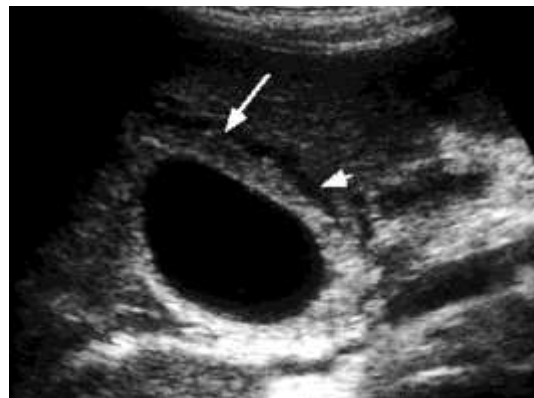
Ultrasound of the right upper quadrant in a patient with acute cholecystitis reveals marked thickening of the gallbladder wall (arrow) with fluid surrounding the distended gallbladder (arrowhead)
